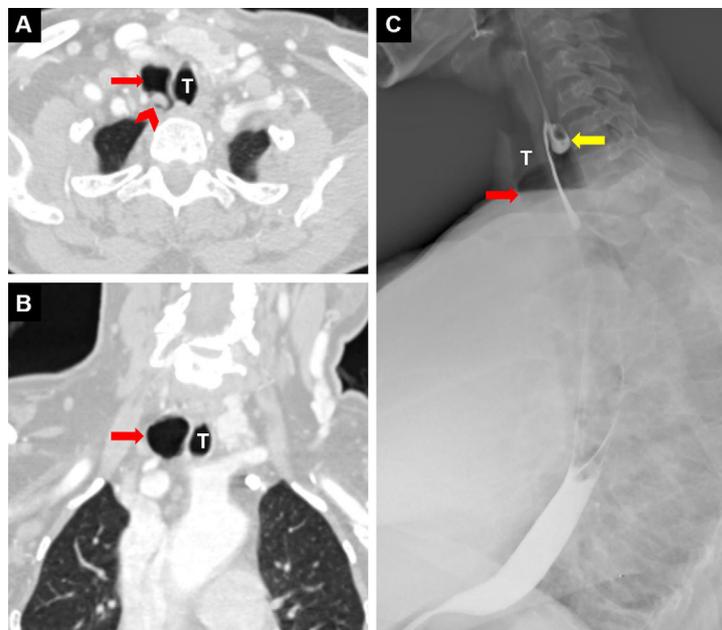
Thoracic computed tomography (CT) axial (A) and coronal (B) section reveals tracheal diverticulum (red arrow) and mucus secretion within the diverticulum (arrowhead). Barium esophagogram (C) reveals esophageal diverticulum proximally (yellow arrow) and anteriorly air from tracheal diverticulum (red arrow). T: trachea.
